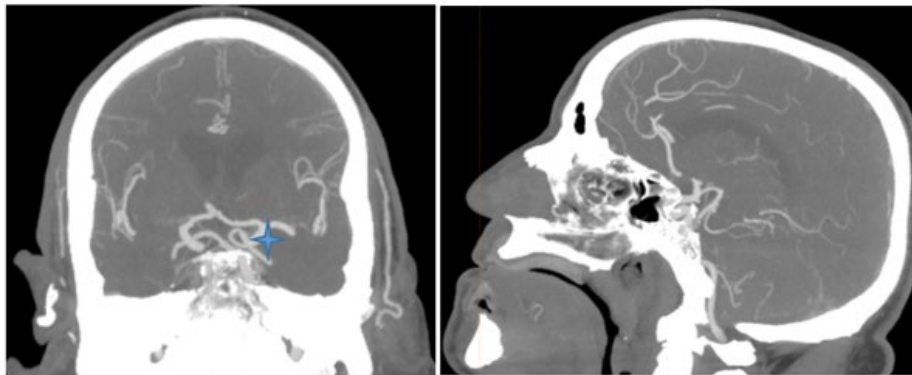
Brain CT scan in coronal and sagittal sections after contrast injection showing a dilated appearance of the posterior communicating artery, forming a loop-like structure (Asterisk).
